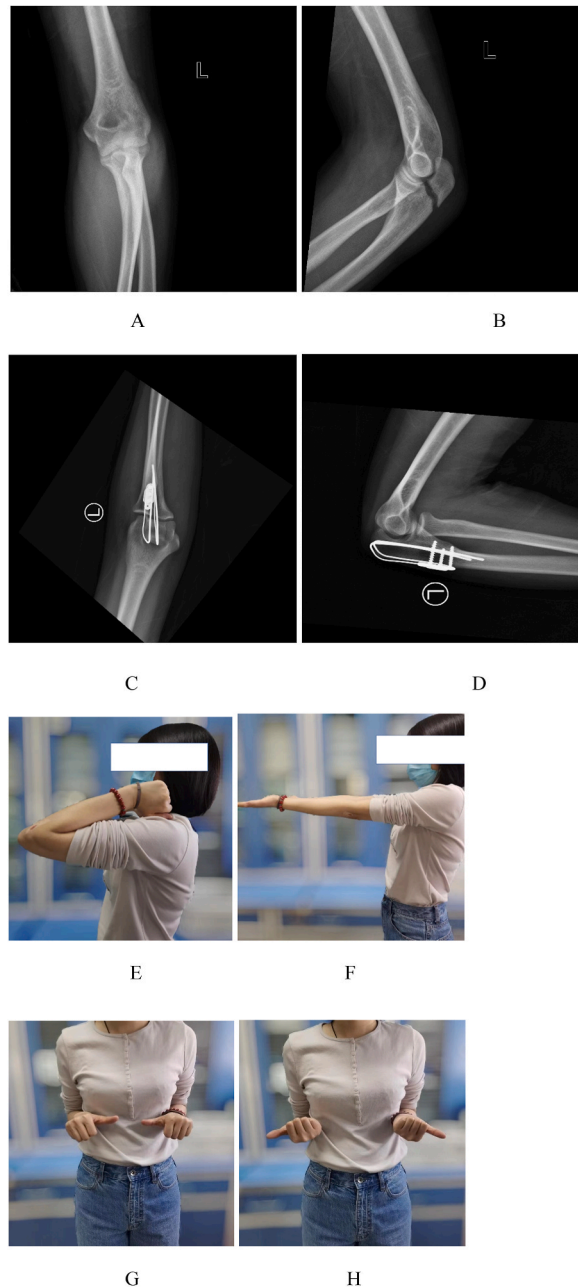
Female, aged 23, anteroposterior (A) and lateral (B) X-ray showing olecranon fracture preoperatively. Anteroposterior (C) and lateral (D) X-rays showing union of the fracture 28 months after the operation. Clinical photographs (E, F, G, H) showing final full range of motion.
